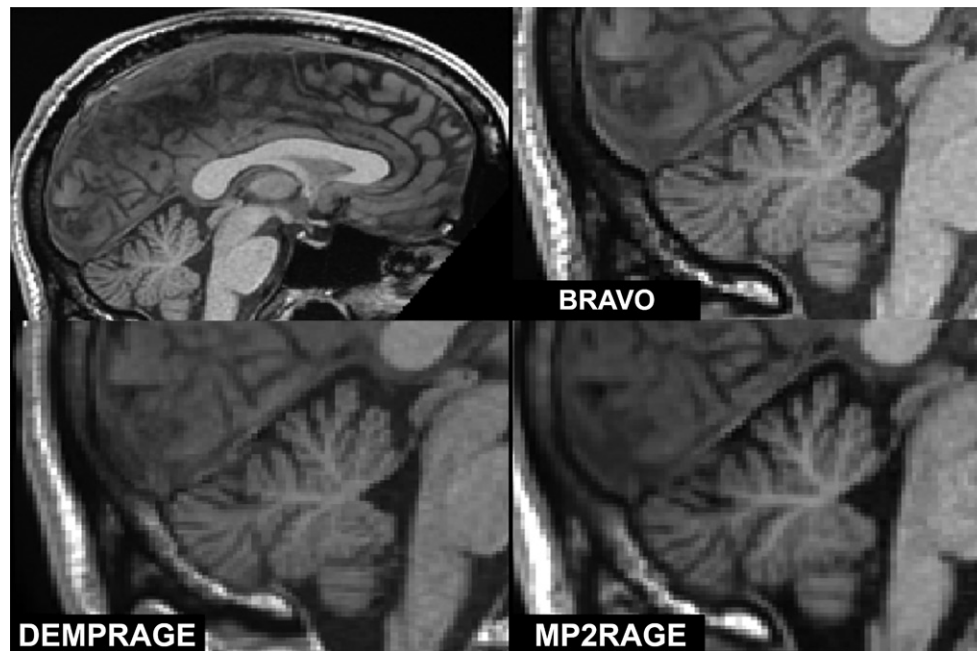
MR images depict the various modalities collected. Top row depicts BRAVO, bottom left depicts DEMPRAGE, and the bottom right depicts MP2RAGE.
